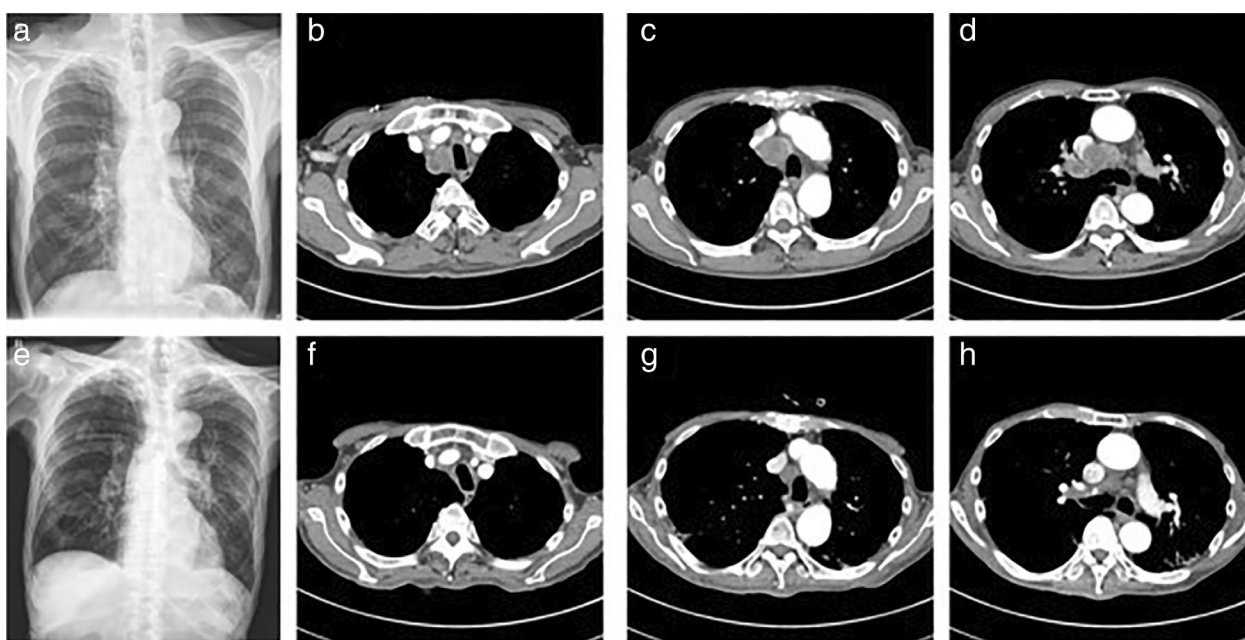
The posteroanterior (PA) chest X-ray and chest computed tomography (CT) scan. (a) Initial chest PA showed mediastinal widening and thickened paratracheal stripe; (b)–(d) initial chest CT scan revealed enlarged mediastinal lymph nodes (LNs) and mass; (e) chest PA after two cycles of chemotherapy demonstrated decreased sizes of LN and mass; (f)–(h) follow-up CT scan showed remarkable response of tumor after chemotherapy
